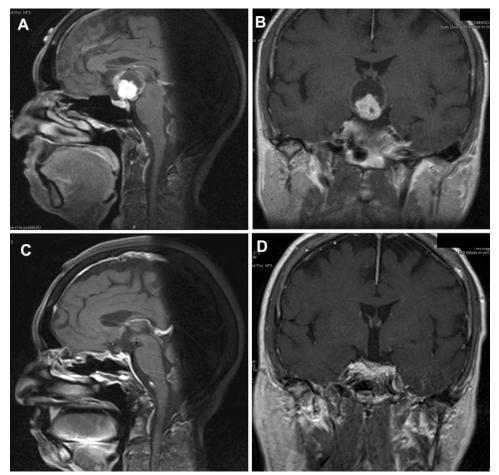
Complete resection by initial postoperative MR imaging but incomplete removal by endoscopic surgical assessment. A and B: Preoperative sagittal and coronal T1-weighted MR images. C and D: Postoperative sagittal and coronal T1-weighted MR imaging showing apparent complete resection. However, intraoperative endoscopic inspection indicated residual tumor (see Video 1).
